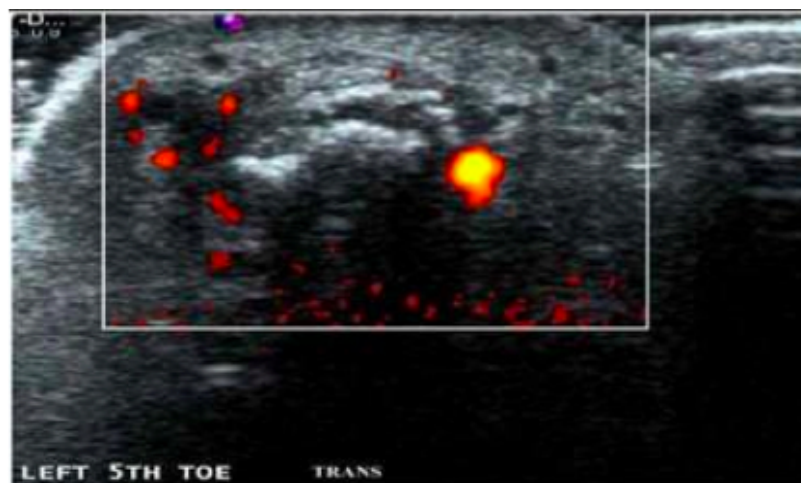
A power Doppler ultrasound image of a 5th metatarsal BSI.
